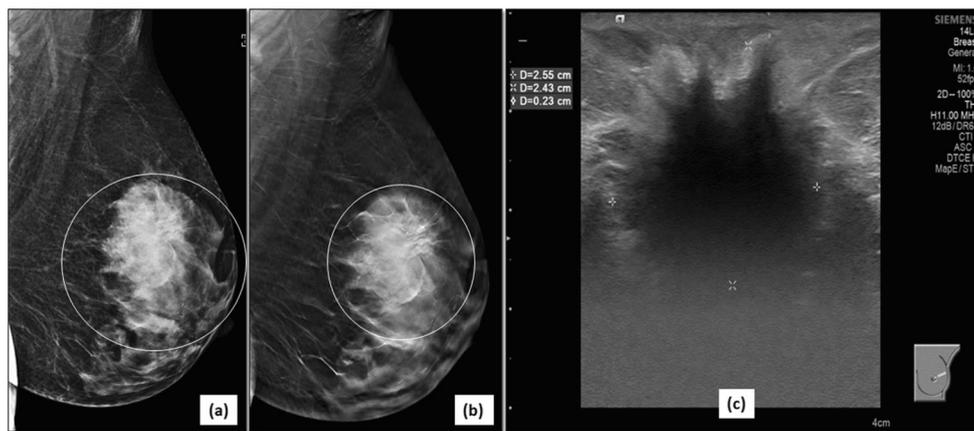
Better margin characterization in a dense breast: 2D-MLO view (a) of the left breast shows a large irregular mass (circle) in the upper quadrant of left breast. The spiculated margins (circle) are better demonstrated on DBT image (b). Corroborative ultrasound (c)
